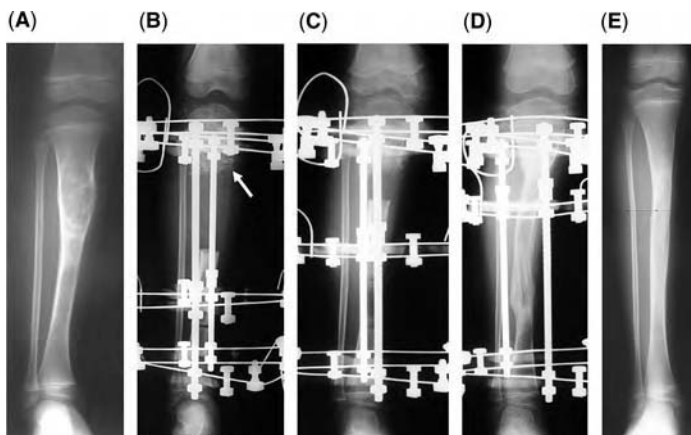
Type 1 diaphyseal reconstruction. (A) A six-year-old boy showed a recurrent juvenile adamantinoma in the midshaft of the right tibia. A 7.2 cm en bloc tumor excision was performed. (B) The diaphyseal defect was reconstructed by bone transport using an Ilizarov apparatus. Allogenic cancellous bone was grafted to the expected docking site. (C) Radiograph during bone transport. (D) Radiograph after completion of transport. The cancellous allograft was compressed. Good regeneration was seen. (E) Full remodeling of the tibial midshaft was seen six years after the operation. Neither tumor recurrence nor deformities were observed.
